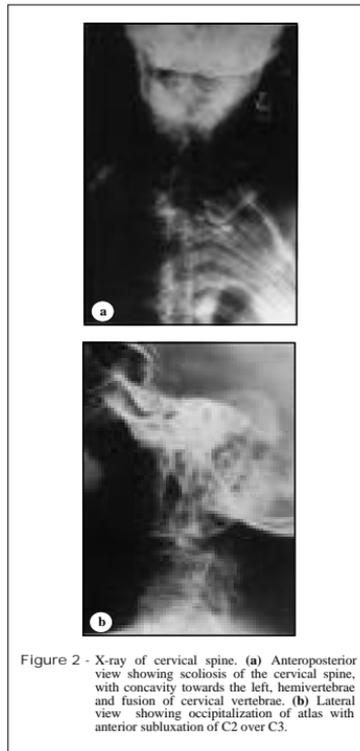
X-ray of cervical spine. (a) Anteroposterior view showing scoliosis of the cervical spine, with concavity towards the left, hemivertebrae and fusion of cervical vertebrae. (b) Lateral view showing occipitalization of atlas with anterior subluxation of C2 over C3.
